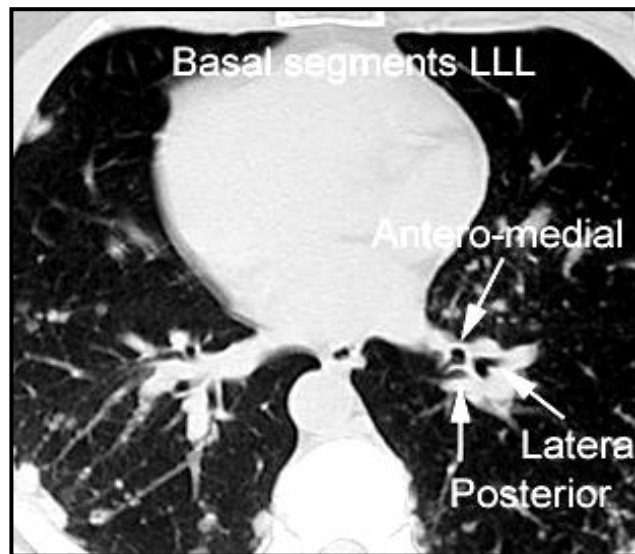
axial CT cuts of the segmental branches of the Left main bronchus (*Gruden, et al, 2000*).
